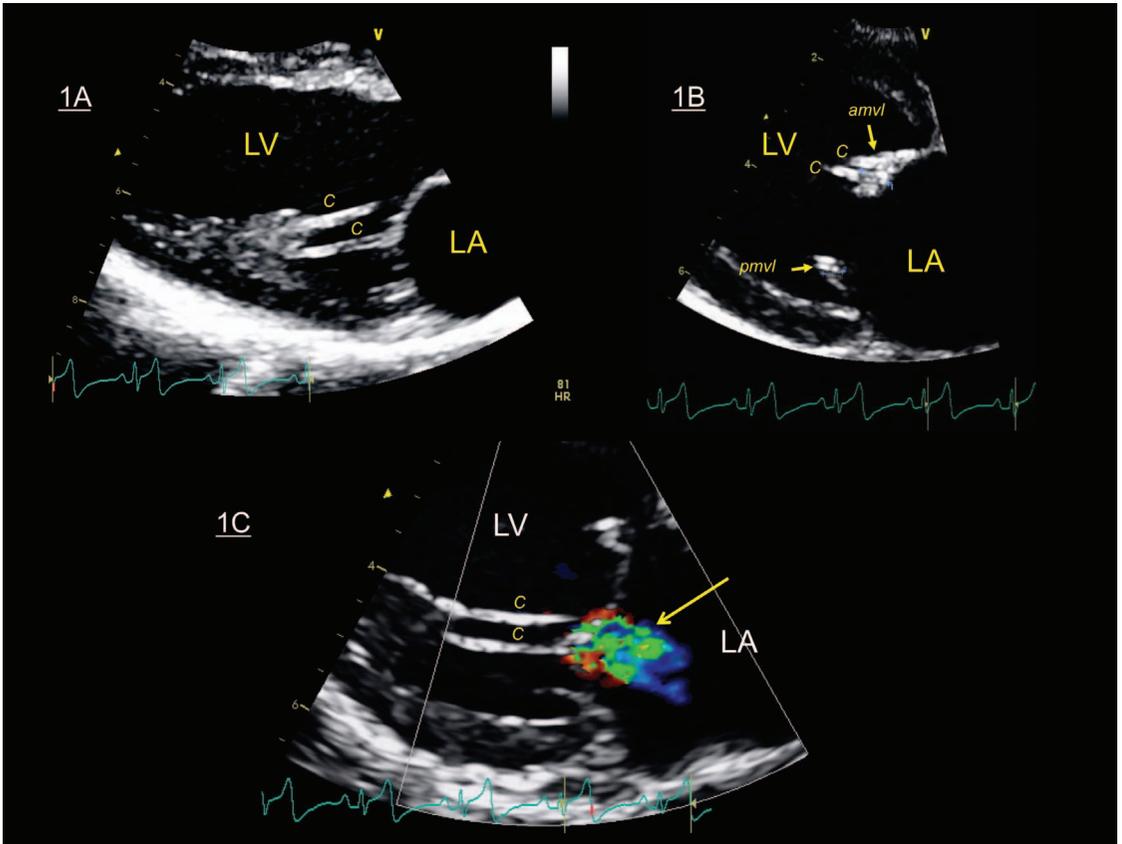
(A–C) – Two-dimensional (A, B) and color-flow Doppler mode (C) echocardiograms obtained from right parasternal long-axis views in an “apparently healthy” snow leopard (*Uncia uncia*). Mitral valve lesions are characterized by the presence of irregular and thickened mitral valve leaflets as well as thick and hyperechoic chordae tendineae. (C) The turbulent but mild end-systolic mitral regurgitation (arrow). C indicates chordae tendineae; amvl and pmvl, anterior and posterior mitral valve leaflets, respectively; LA, left atrium; LV, left ventricle.
